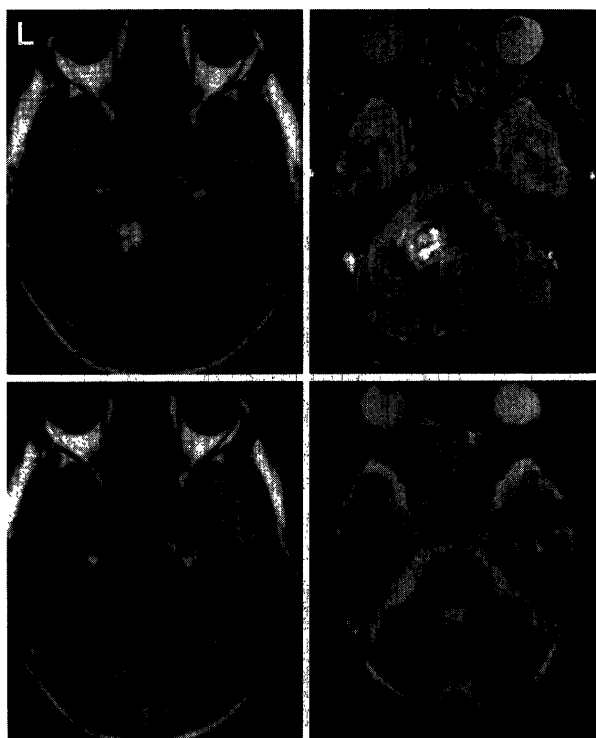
Case 3. *upper*: T<sub>1</sub>- (*left*) and T<sub>2</sub>-weighted (*right*) SE MR images, showing a heterogeneous lesion with low-intensity rim in the left lateral tegmental area extending into the middle cerebellar peduncle. *lower*: T<sub>1</sub>- (*left*) and T<sub>2</sub>-weighted (*right*) SE MR images 2.5 years later, showing a slightly different, but essentially heterogeneous lesion at the same location.
